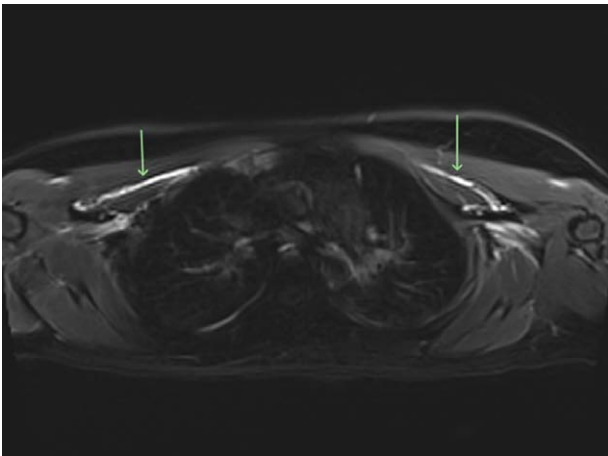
Coronal MRI demonstrating interpectoral block.
